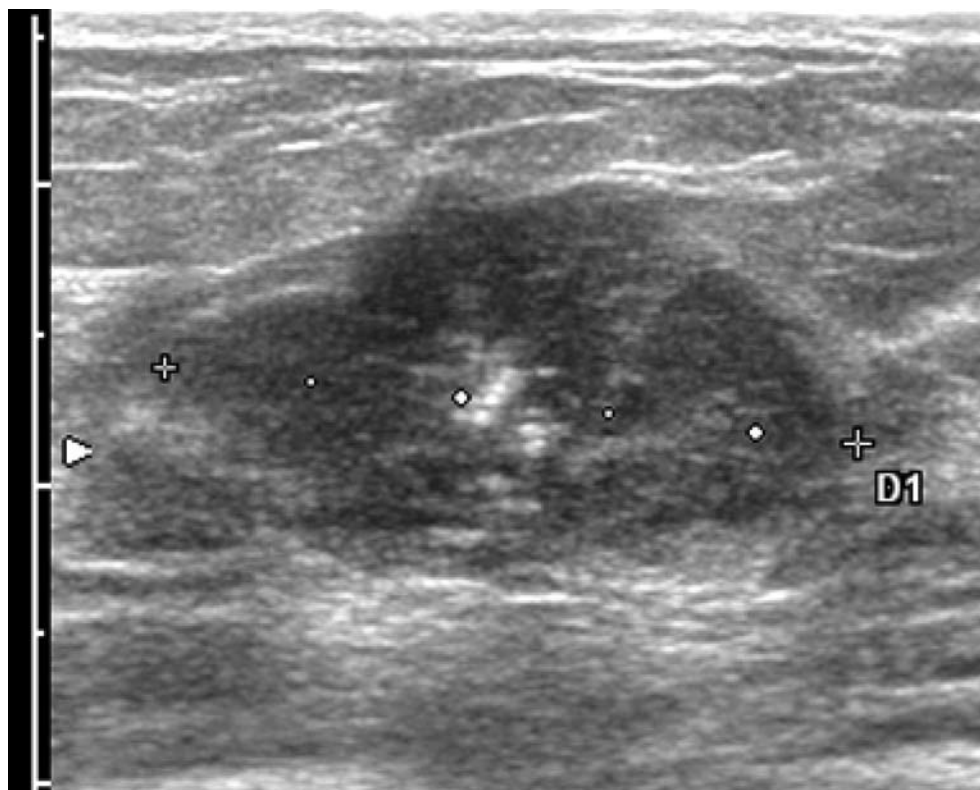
Ultrasonography revealed a low-echoic lesion with a highly echoic central spot.
